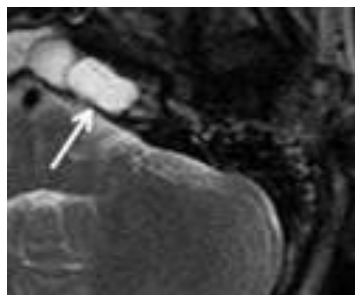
Meningocele axial T2-weighted note that the lesions demonstrate a signal identical to that of CSF, and are located in the petrous apex.
